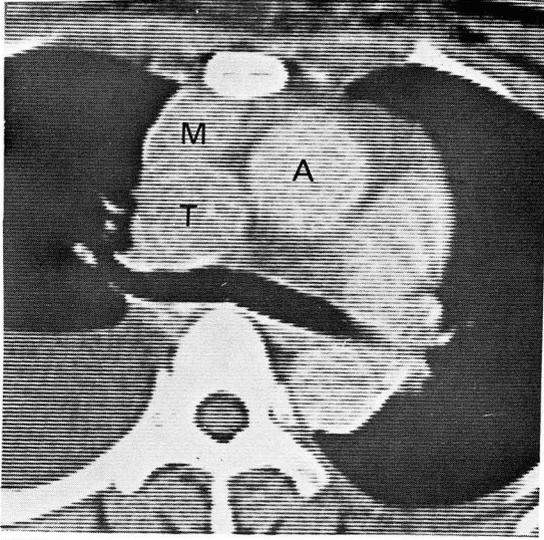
a: CT scan at the level of carina. Contiguous anterior mediastinal (M) and intracaval tumor mass (T) is seen. Right pleural effusion. A=Ascending aorta.
